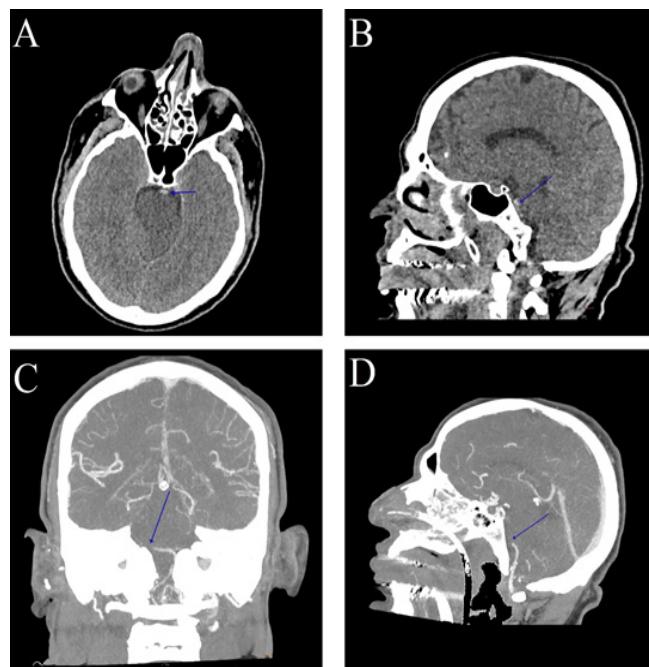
Non-contrast cranial CT in axial view (A) and sagittal view (B) showing the hyperdense artery sign in the basilar artery—basilar artery thrombosis (blue arrow). (B) Cranial CT angiography in MIP (maximum intensity projection) in coronal view (C) and sagittal view (D) showing a filling defect in the basilar artery due to contrast, characterizing basilar artery thrombosis (blue arrow).
